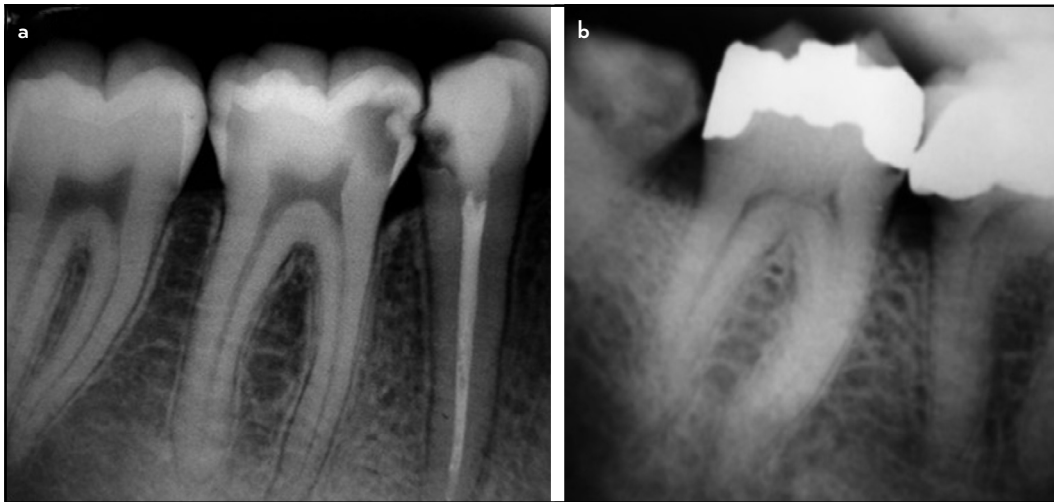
Examples of mandibular molars with (a) prominent and (b) receded pulp horns identified on periapical radiographs
